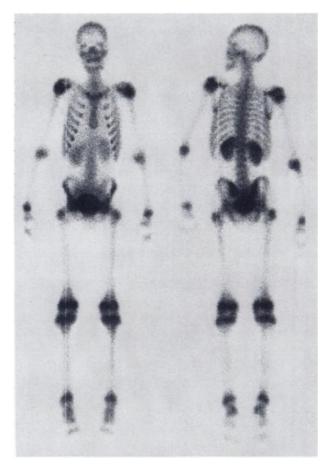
Normal anterior and posterior Tc-99m pyrophosphate bone scintigrams of 15-year-old boy with leukemia.
